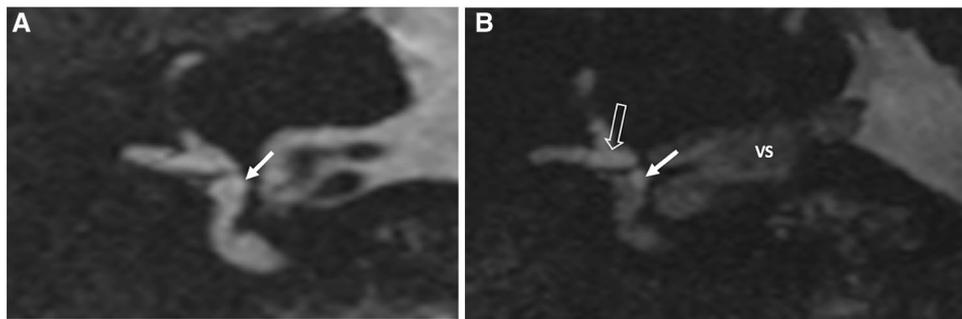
a Normal saccule (arrow) and normal hyperintense signal of the perilymphatic and endolymphatic fluids on T2-weighted images. b Normal saccule in a patient with a VS, height ≤ 1.6 mm, width ≥ 1.4 mm (arrow). The endolymph, comprising the saccule
